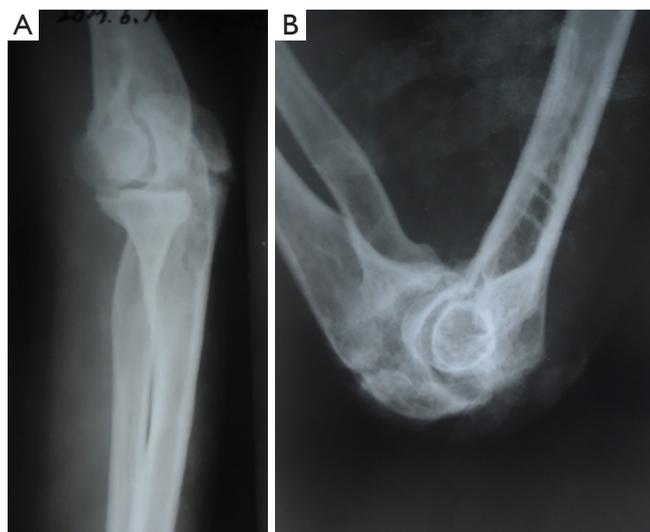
X-ray view of the elbow after removal of HO and implants. (A) Lateral radiograph view of the extended elbow. (B) Lateral radiograph view of the flexed elbow.
